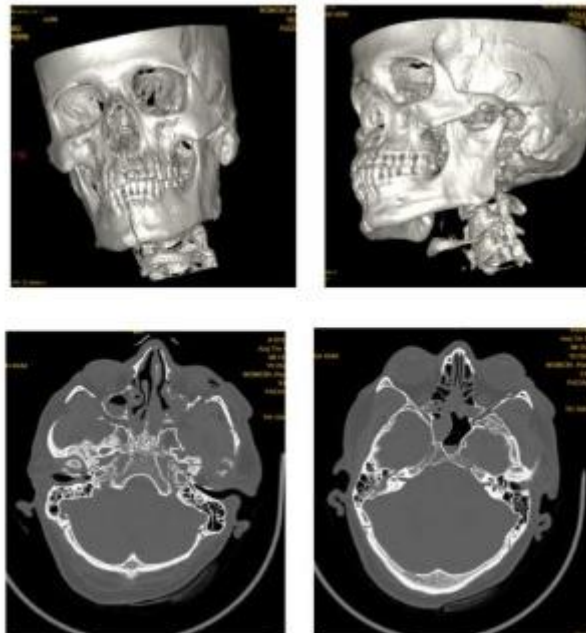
Sequence of images [31]-CT (A-B), axial shows depressed fracture in the left anterior maxillary wall, and comminuted displaced fracture of posterolateral wall of the maxilla. There is comminuted fracture in the left zygoma and a linear fracture in the body of mandible. A linear undisplaced fracture in the squamous part of left temporal bone noted.
